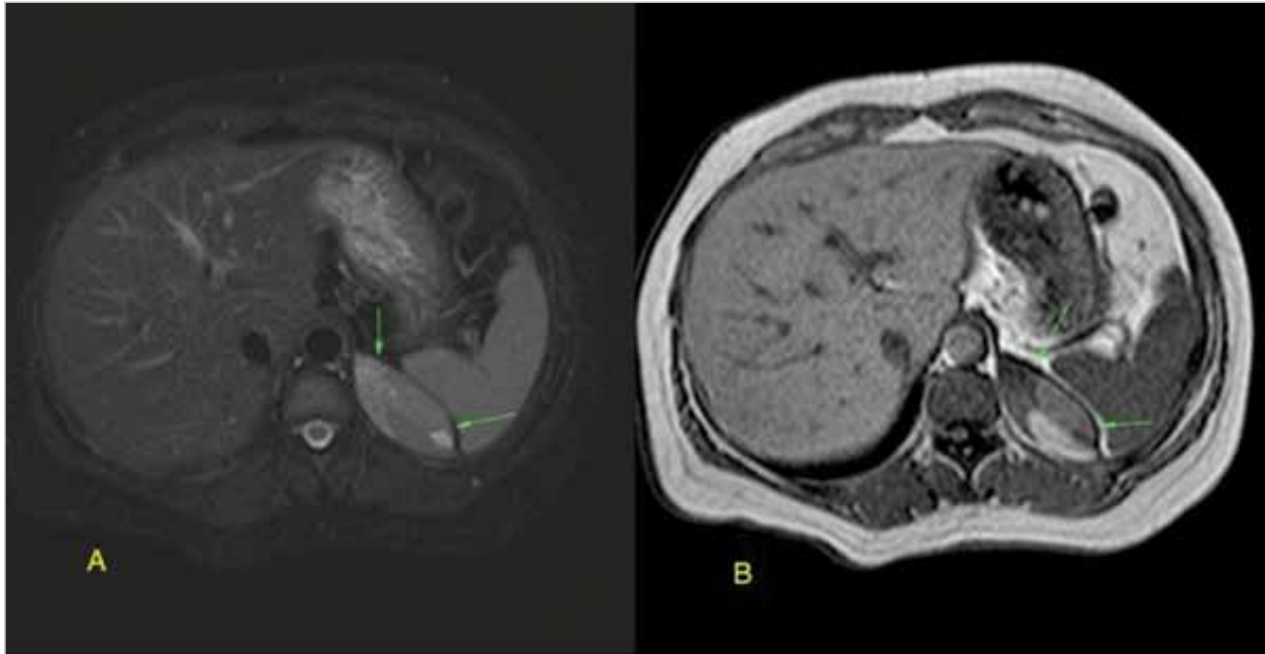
a, b. Axial turbo spin-echo T2-weighted (a) and T1-weighted (b) images reveal a well-defined, ovoid, heterogeneous lesion with hyperintense components (arrows) in the left suprarenal region abutting the diaphragmatic crus
